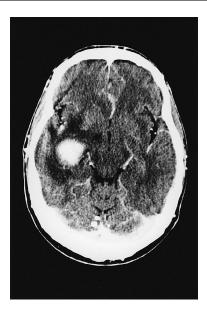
Intracerebral bleeding in Klippel—Trénaunay Syndrome. The CT scan reveals a hyperdense contrast enhancing lesion in the right temporal lobe with surrounding edema and slight mass effect, marked enhanced choroid plexuses and occipital cerebral calcifications.
